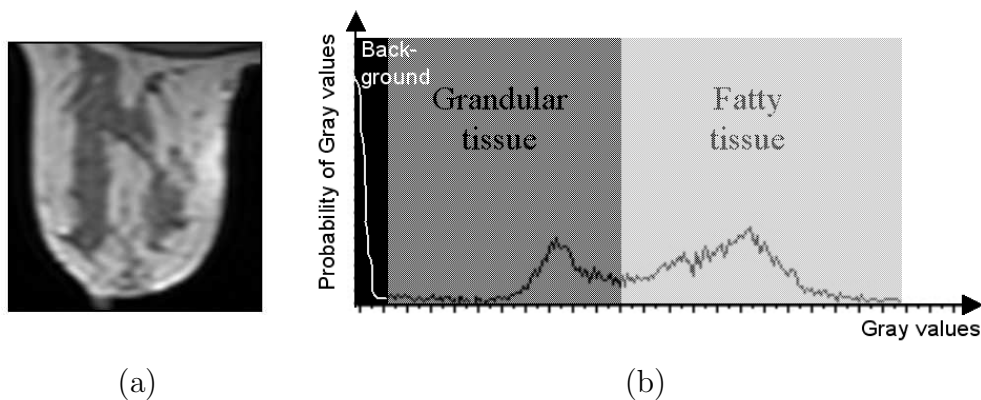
An example of MRI histogram.(a) Original MRI slice, (b) Histogram.
